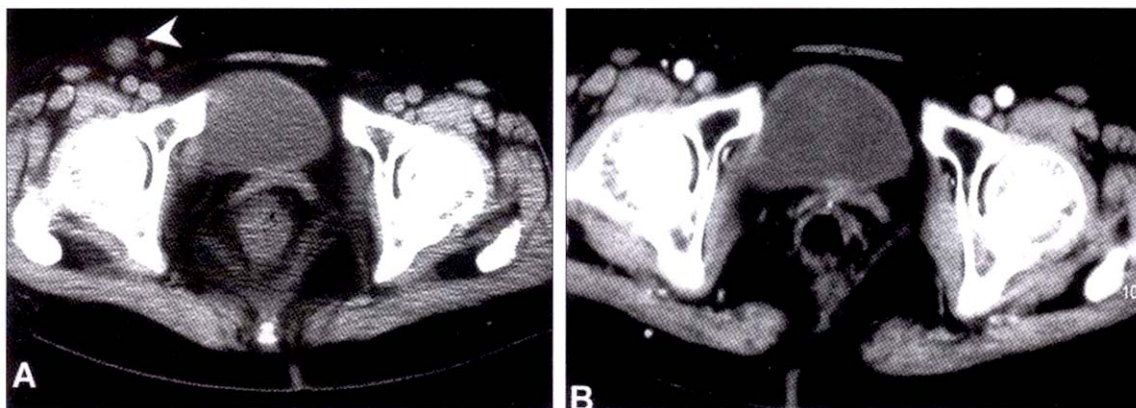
CT scan of pelvis revealed enlarged right inguinal lymph node (arrowhead) (A). After final treatment, the right inguinal lymph nodes decreased in size (B).
